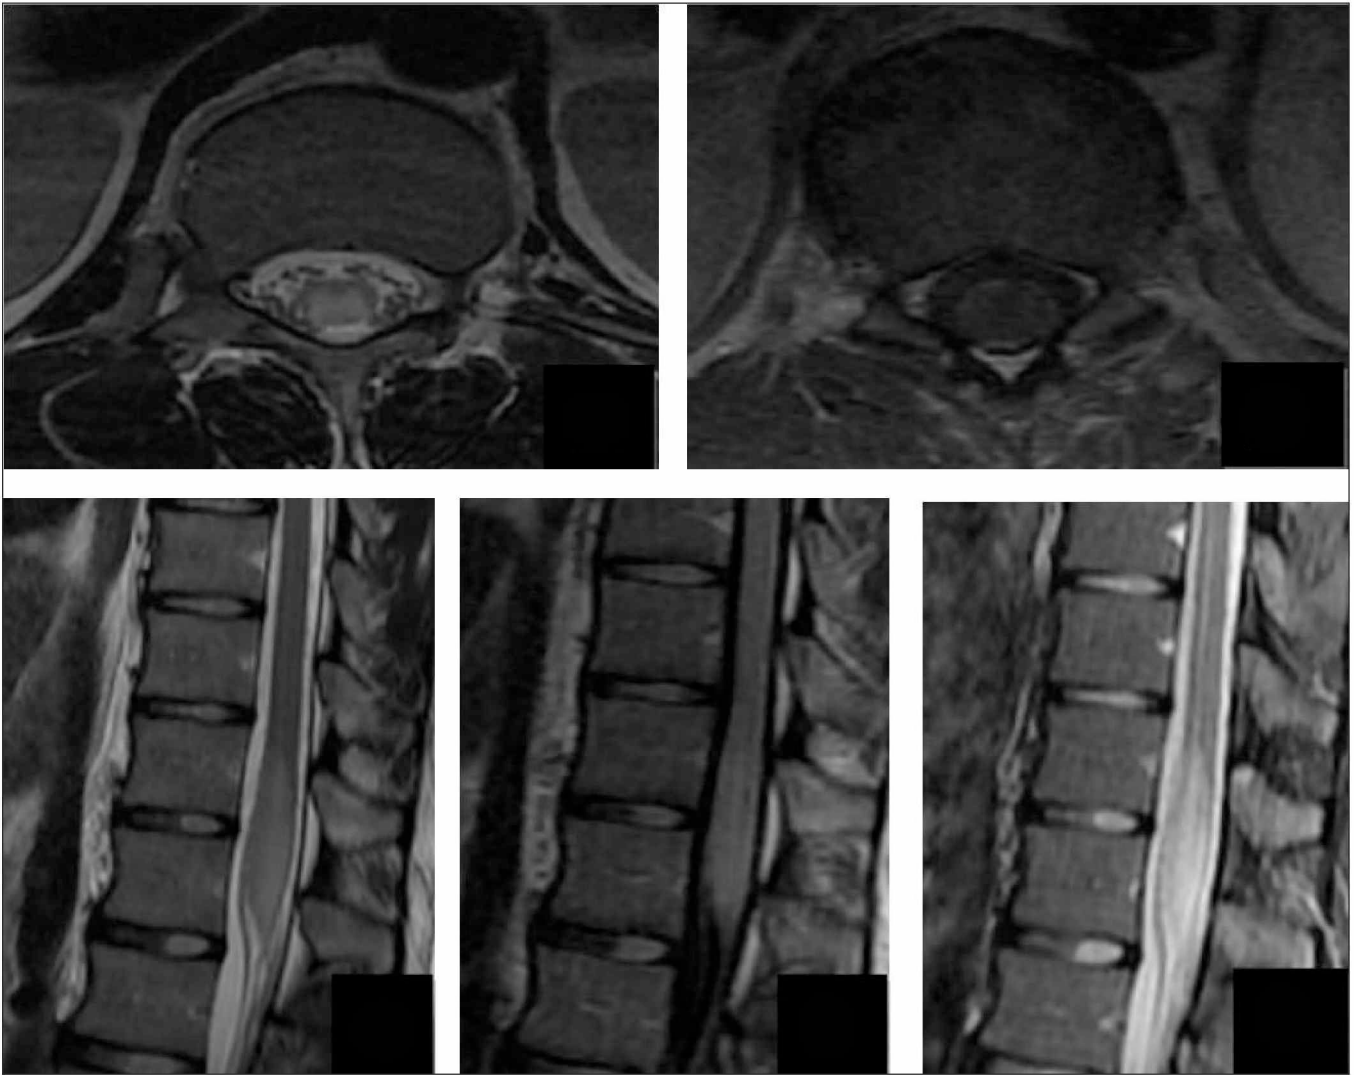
MRI of the patient's thoracic spine, sagittal projection (T2 FLAIR, STIR, and T2W sequences) and coronary projection (T2W).
